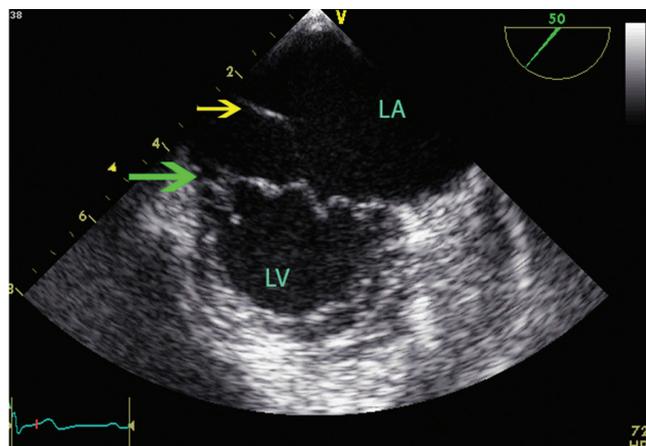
Transesophageal echocardiography in the short-axis view (50°) shows the site of the avulsion of the P3 (small arrow). Additionally, a mass is seen in the LA (large arrow).
